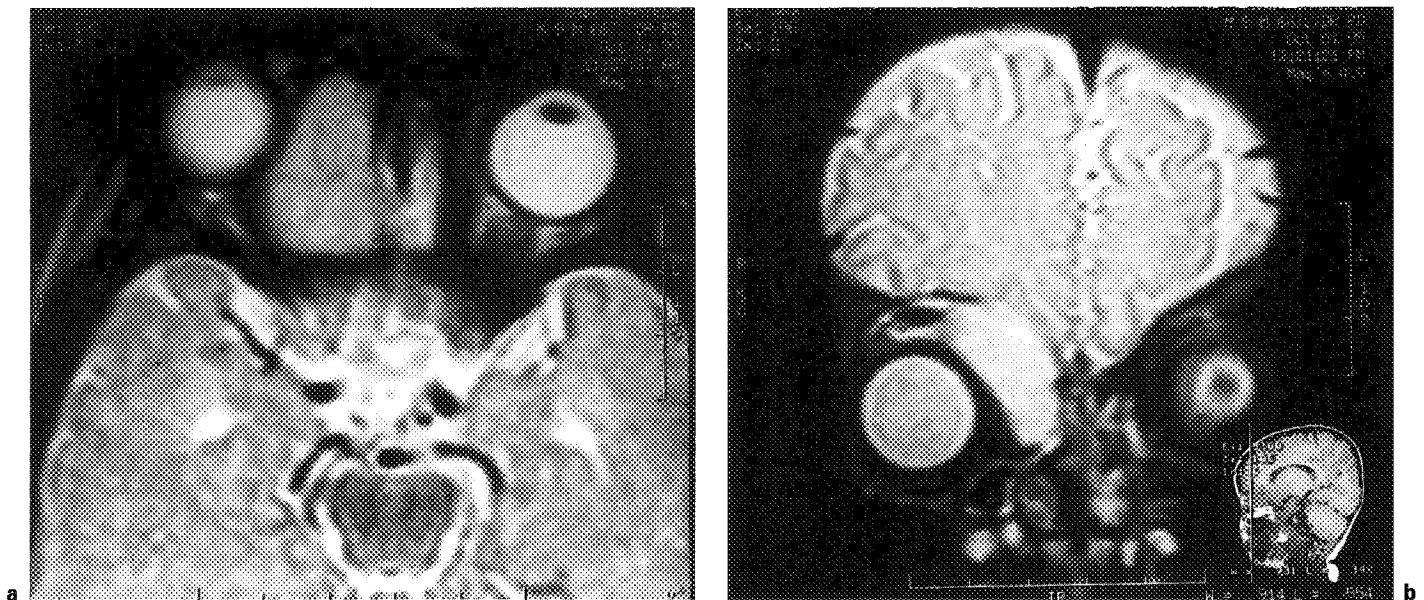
MRI scan, T₂-weighted images; axial (a) and coronal view (b) showing mildly hyperintense lesion in the same location.
